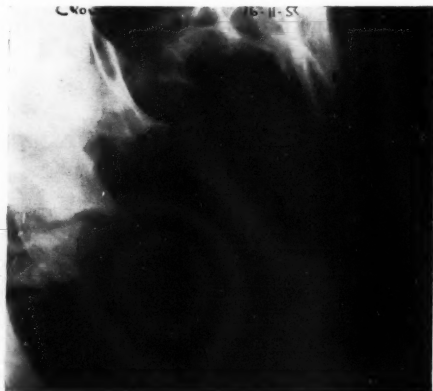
Lateral oblique radiograph showing two inverted teeth in the 54 region.
